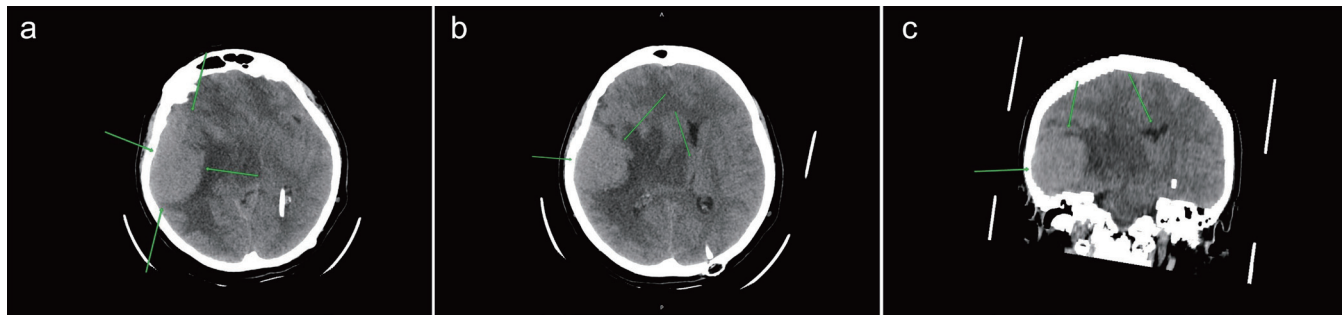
Space-occupying lesion in the right temporal lobe parenchyma. On a series of non-contrast brain computed tomography scans, a homogeneous hyperdense lesion with well-defined margins is visualized within the right temporal lobe parenchyma (a), surrounded peripherally by a hypodense zone representing brain tissue edema (February 2, 2022). There is displacement of midline structures to the left (b), along with compression and deformation of the ventricular system (c).
